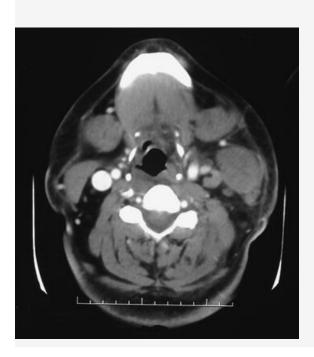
Axial computed tomography scan showing isolated oedema of the sternomastoid muscle, with intact fascial planes and absence of collection or lymphadenopathy
